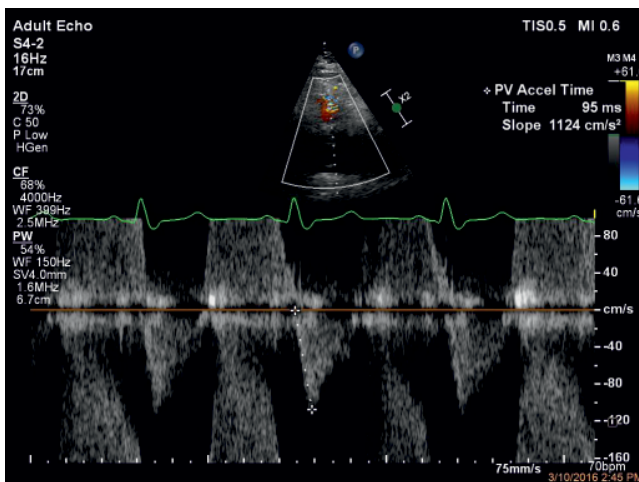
Transthoracic echocardiography parasternal short axis view, pulsed wave Doppler, PVAT 95 msec.
